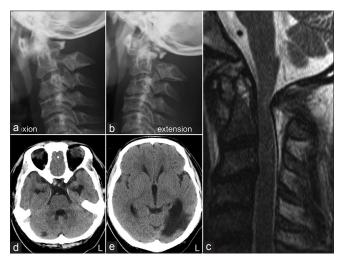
Initial radiographical examinations. (a and b) Dynamic lateral radiographs of the cervical spine in flexion (a) and extension (b) positions showing AAS without complete reduction of the atlantoaxial joint. (c) Preoperative sagittal T2-weighted MRI of the cervical spine showing cervical canal stenosis with intramedullary signal change at the CI level. (d and e) Axial CT images of the brain. Low-density areas in the right superior cerebellar artery area (d) and in the left posterior cerebral artery area (e) indicate subacute infarctions
